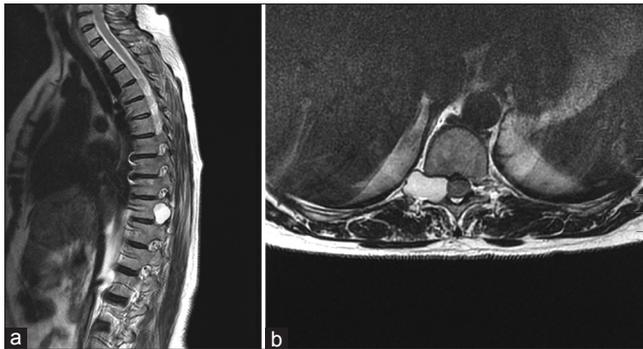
Sagittal (a) and axial (b) thoracic spinal T2-weighted magnetic resonance imaging sequences confirmed the presence of a hyperintense extradural lesion determining also T10 vertebral body scalloping.
